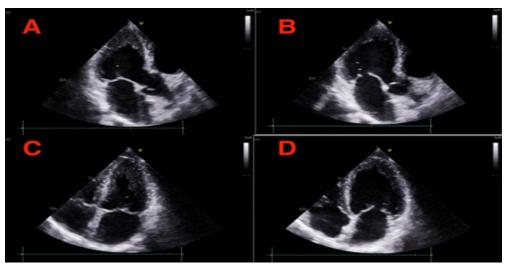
Echocardiogram at the time of admission with explanations. (A) Parasternal long axis at the end of systole (B) Parasternal long axis at the end of diastole (C) 4 chamber view at the end of systole (D) 4 chamber view at the end of diastole. The distinctive octopus trap-shaped appearance of the heart is indicated by markings on images A and C. Additionally, a red arrow highlights the presence of a left ventricular thrombus.
